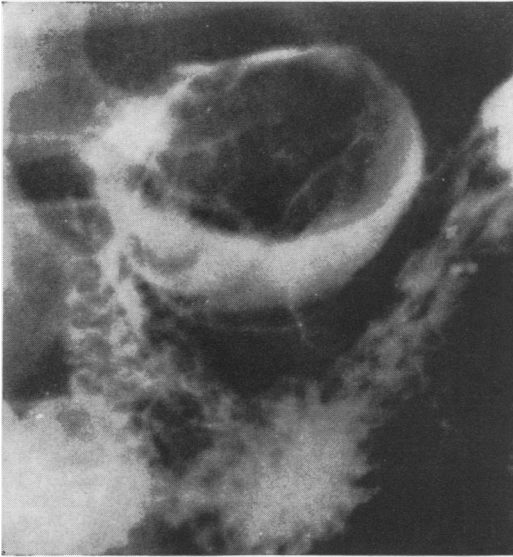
Preoperative radiograph demonstrating duodenal mass that later proved to be Brunner's gland adenoma (Case 1).
